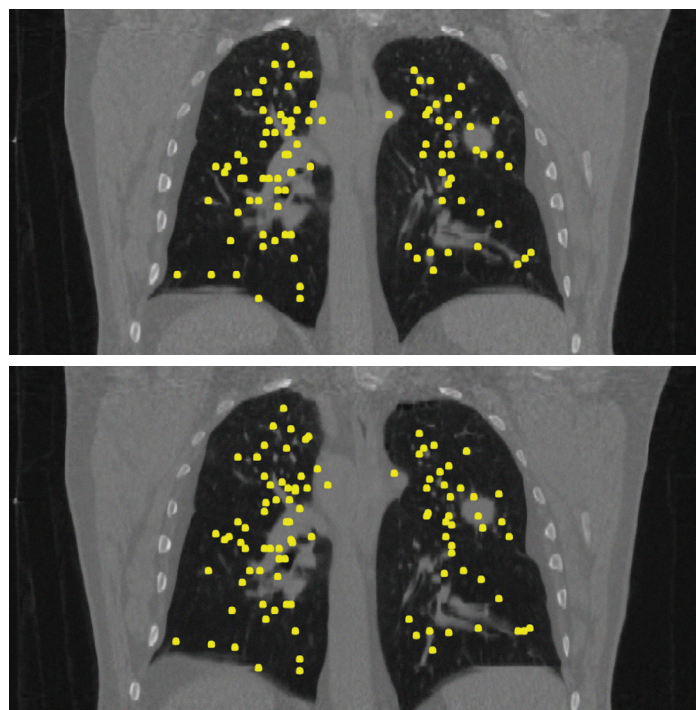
Example of anatomical landmarks manually annotated in end-exhale (top) and end-inhale (bottom) phase of the POPI thoracic 4D CT dataset.
